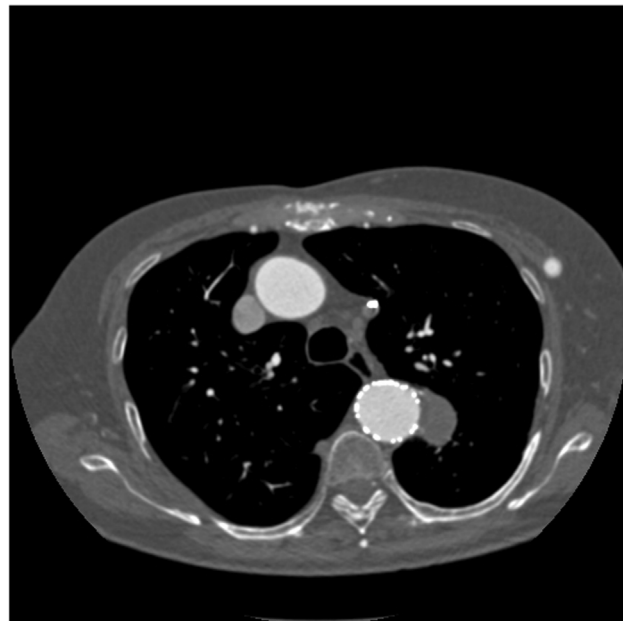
Axial reconstruction of 4-month follow-up computed tomography (CT) scan.
